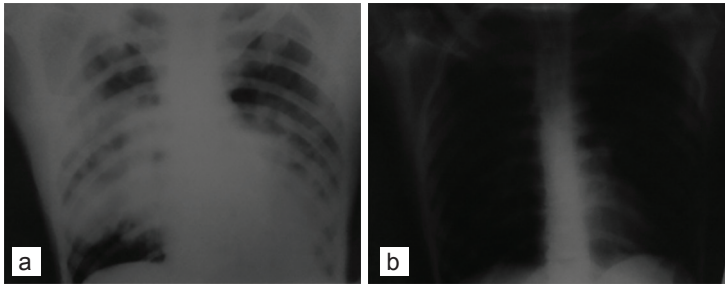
Chest X-ray before (a) and after (b) the treatment
